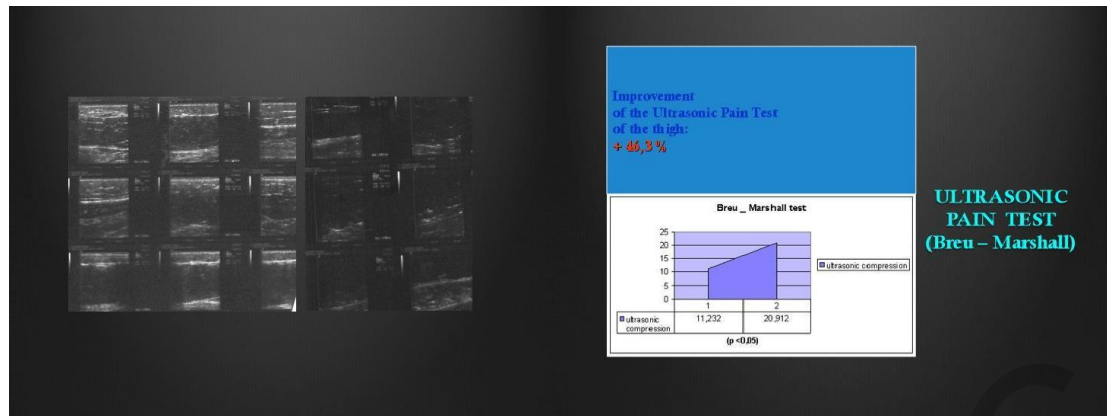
Ultrasonic Pain Test nel Codice TCD (Courtesy Bacci).
